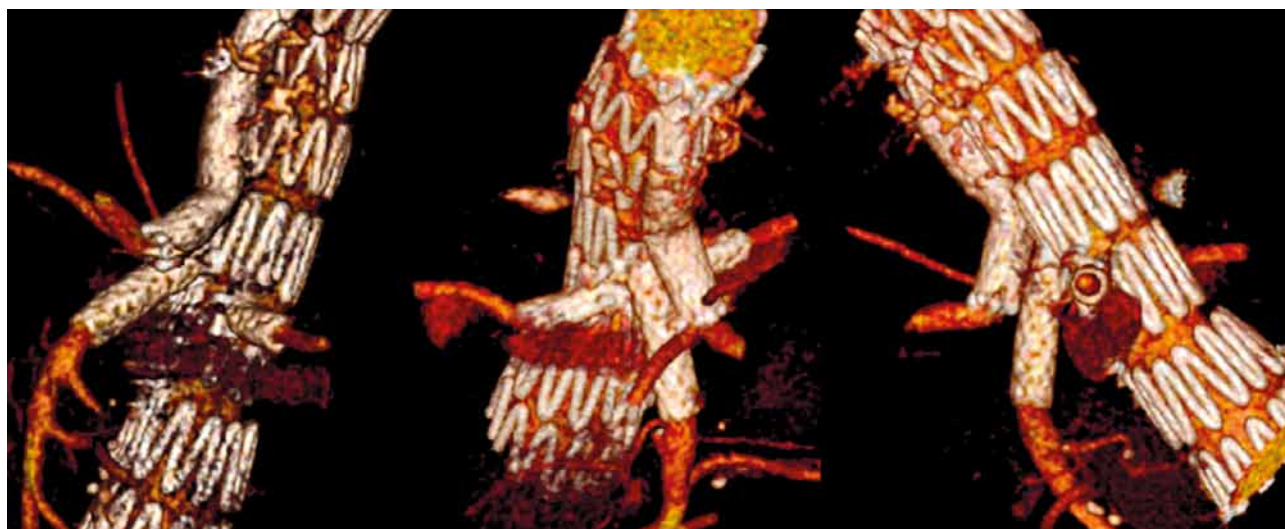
Six-month follow-up three-dimensional CT reconstruction. Properly deployed stent graft in the abdominal aorta and stents in the proximal segments of the visceral vessels (celiac trunk, upper mesenteric and both renal arteries)
